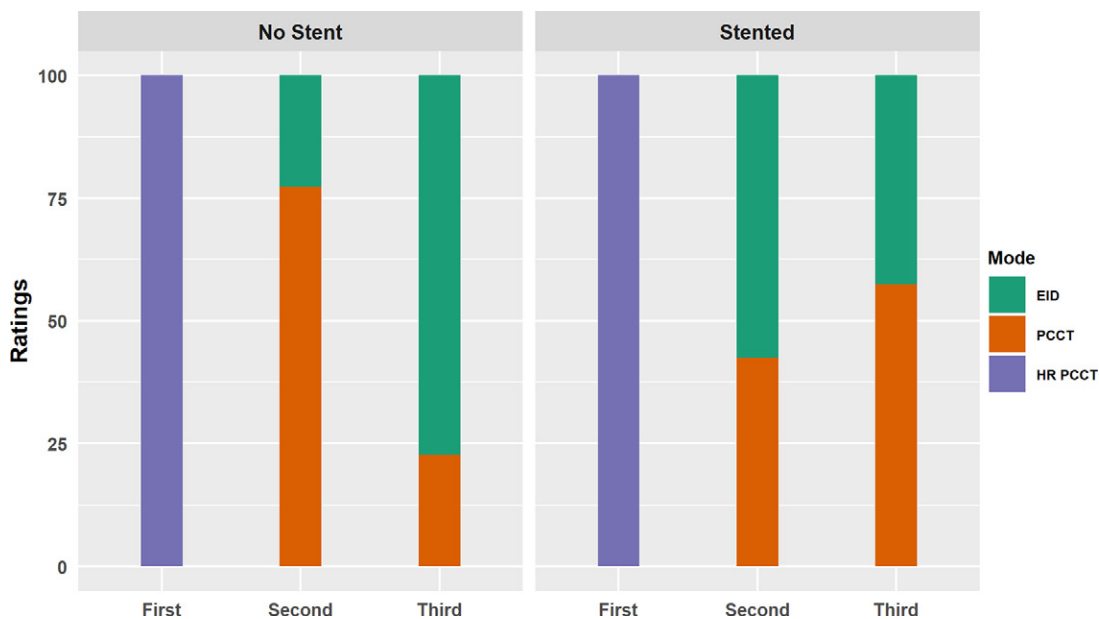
Aggregated results of the observer studies for the unstented (left) and stented (right) cases. For unstented cases, observers were asked to select the image that had the highest plaque conspicuity. For the stented cases, observers were asked to select the image that was least impacted by stent artifact. Rating shown on the x-axis, with each bar representing the percentage of each image mode receiving that score. EID = energy-integrating detector, HR-PCCT = high-resolution PCCT, PCCT = photon-counting CT.
